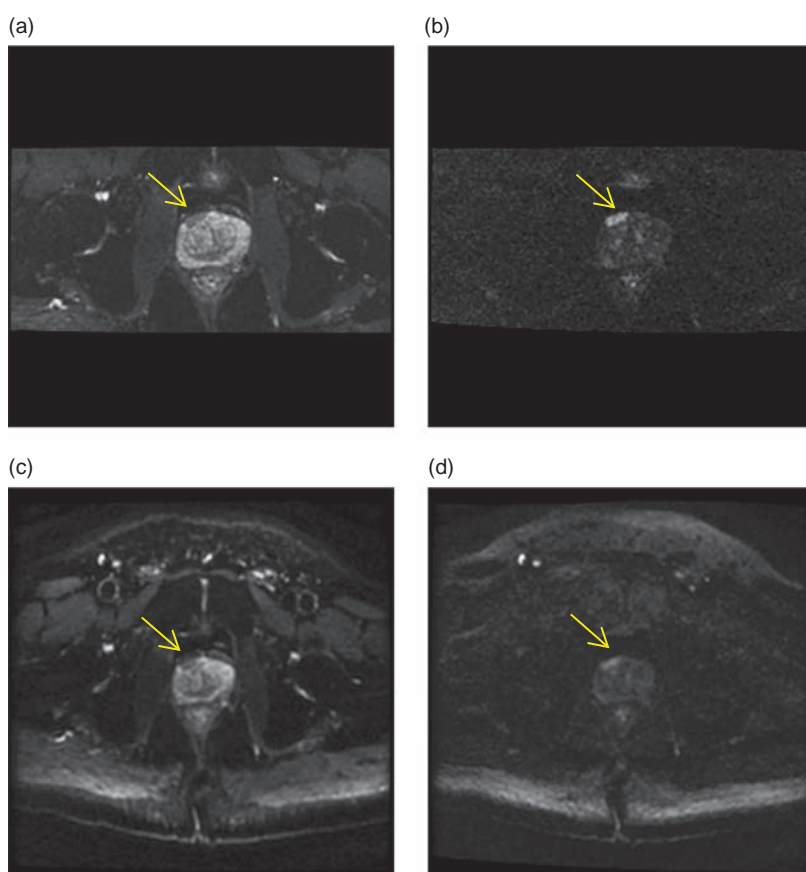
Standard DWI-EPI compared with reduced field-of-view (RFOV) DW-EPI using 2D RF excitation in the prostate. (a) and (b) RFOV DW-EPI with (a) $b = 100 \text{ s mm}^{-2}$ and (b) $b = 1400 \text{ s mm}^{-2}$. Standard DW-EPI sequence with (c) $b = 100 \text{ s mm}^{-2}$ and (d) $b = 1400 \text{ s mm}^{-2}$. Note the improved image quality with the RFOV acquisition.
